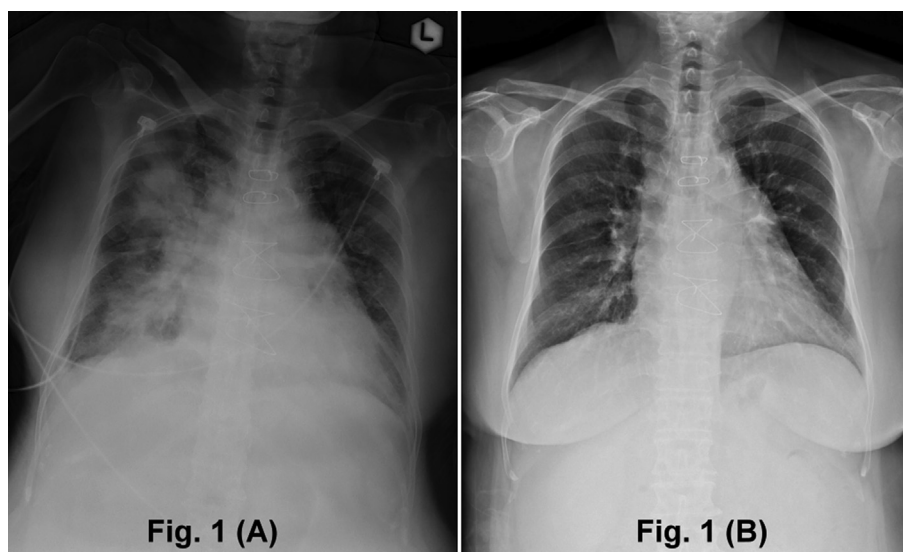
Case 1: chest radiograph showing features of bilateral perihilar edema at presentation (A) and resolution of pulmonary edema after treatment with nitroglycerin and diuretics (B).
